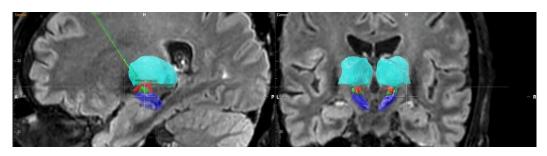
visualizing 3D objects and trajectories in context of the MRI study.
